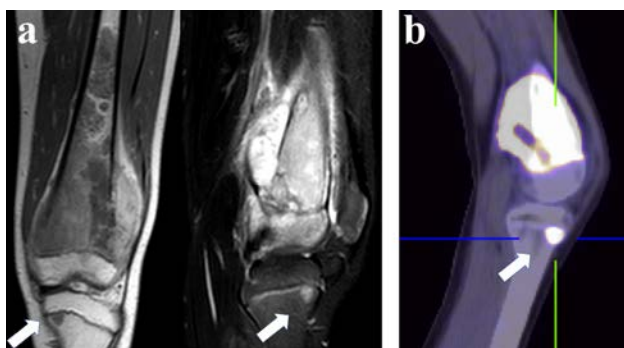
Osteosarcoma of the distal femur. (a) coronal and sagittal MRI show the extensive involvement of the soft-tissue and the intramedullary extension. Moreover, a skip metastasis is identifiable in the tibial growth plate (with arrow); b) PET/CT confirm the increased metabolic activity of both sites.
